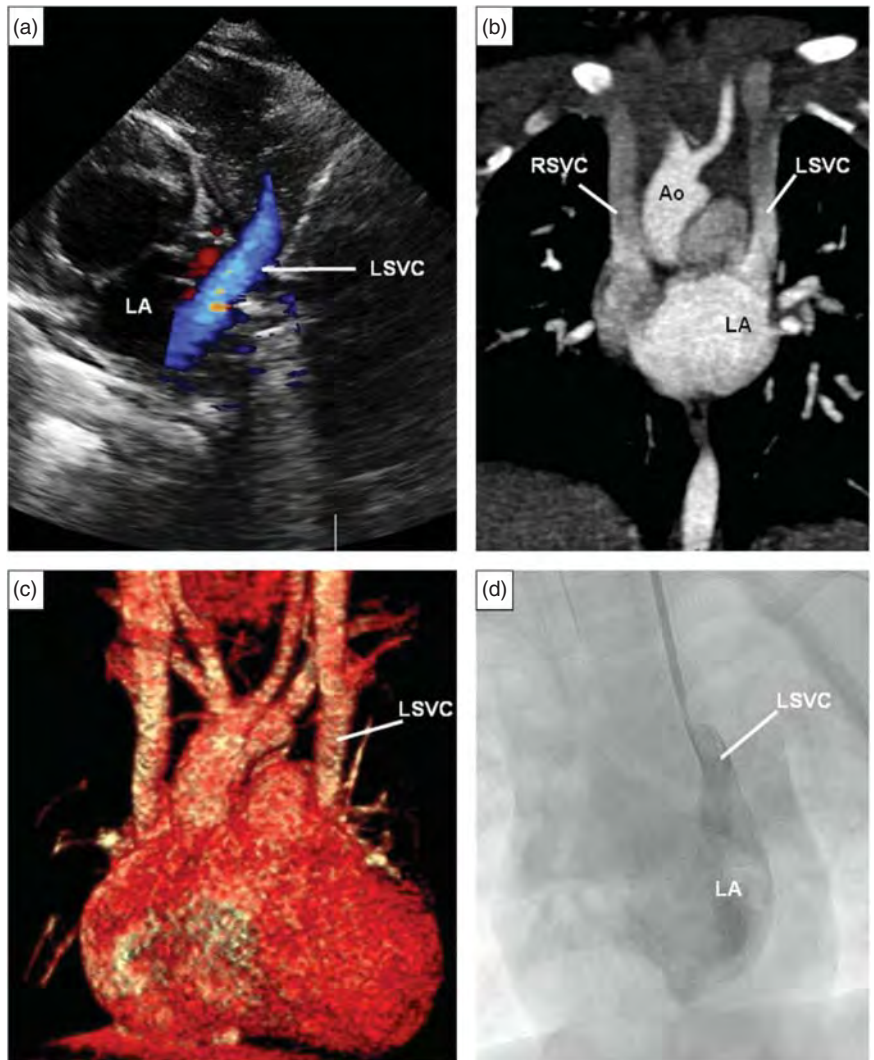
(a) Two-dimensional echocardiography showing the persistent left SVC draining into the left atrium. (b) Computed tomography scan showing bilateral superior venae cavae without the left innominate vein. (c) Three-dimensional CT scan reconstruction showing the absence of communication between the bilateral SVCs. (d) Angiography confirming direct connection of the left SVC to the roof of the left atrium. Ao: aorta; LA: left atrium; LSVC, left superior vena cava; RSVC: right superior vena cava. Source: Tampere *et al.* 2012 [19]. Copyright (C) 2012 Elsevier Masson SAS. All rights reserved. Reprinted with permission.
